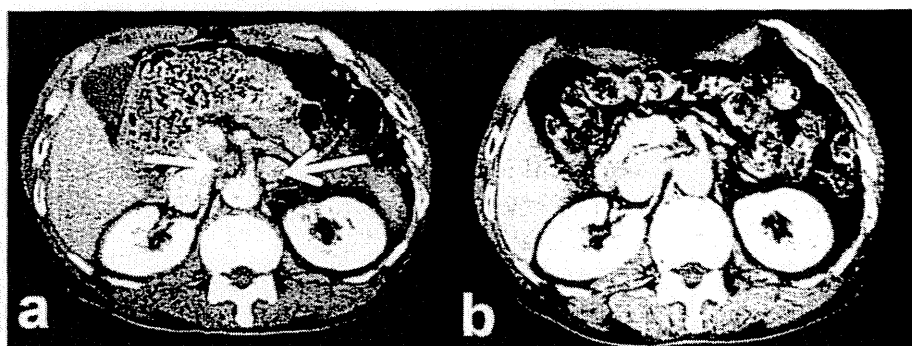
a) Enhanced CT scan demonstrated para-aortic lymphnode swelling (arrows). b) After four courses of neoadjuvant chemotherapy, para-aortic lymphnodes are reduced in size.
